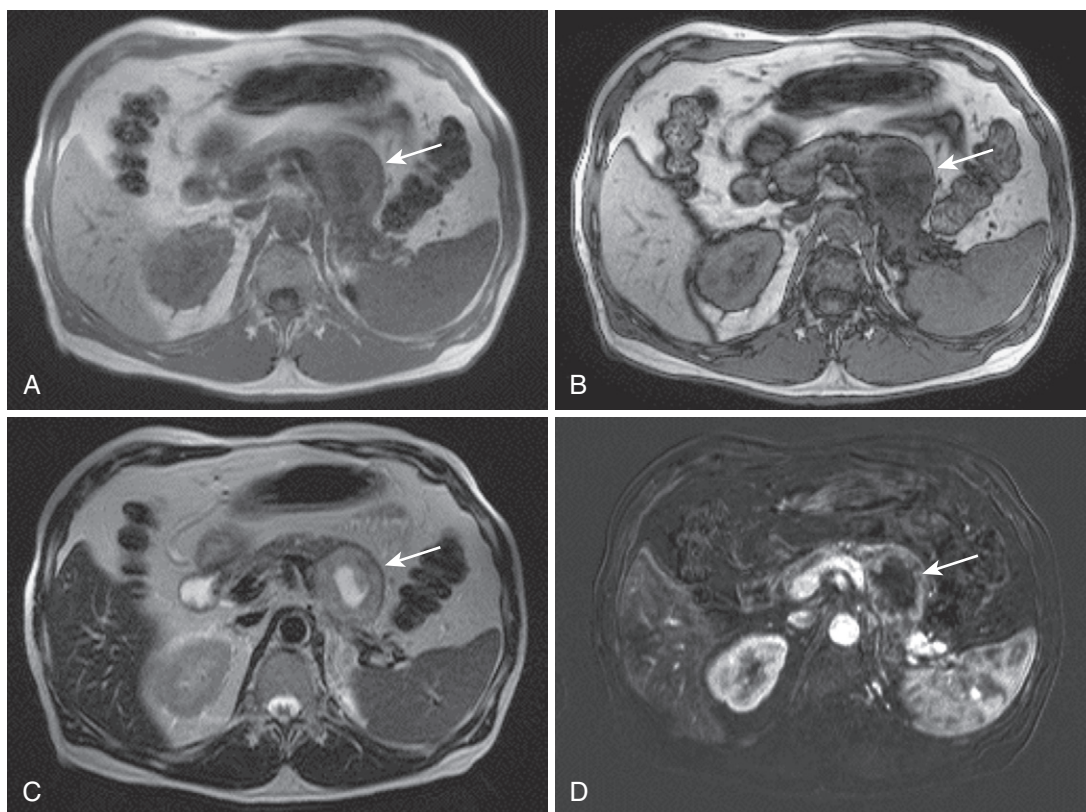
Pancreatic renal cell carcinoma metastases. The in-phase image (A) in a patient with metastatic clear cell renal cell carcinoma shows a large lesion in the pancreatic body (*arrow*), which loses signal on the out-of-phase image (B). Central cystic necrosis and peripheral hypervascularity on the T2-weighted (C) and subtracted arterial phase (D) images reiterate the typical appearance of this type of tumor (*arrow*).
